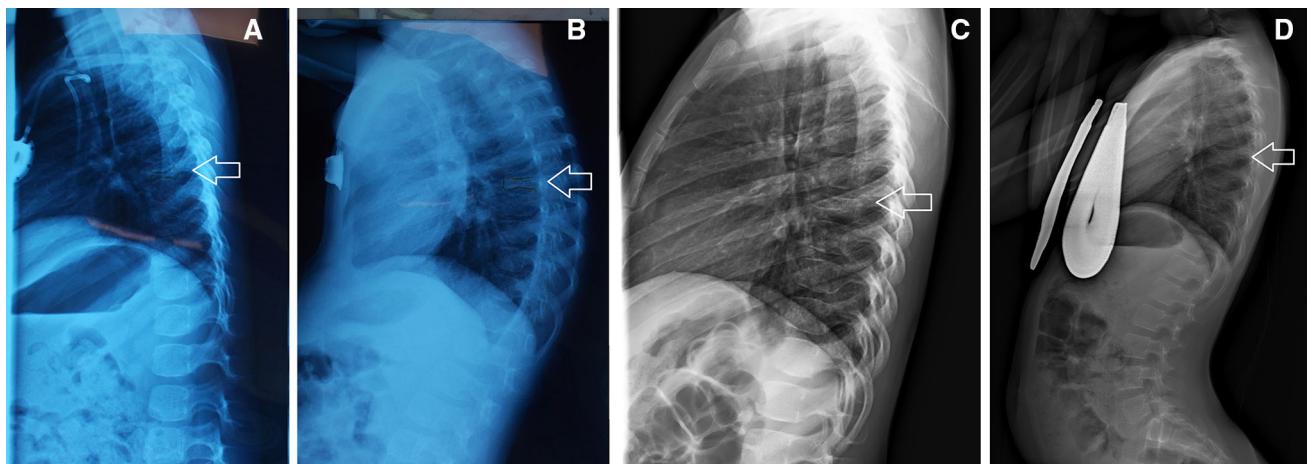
X-ray lateral view of thoracic spine showing a progressive T7 vertebral reconstruction from 2009 to 2015 (arrows); a 2009 6 months after the diagnosis, b 2010, c 2011, d 2015
